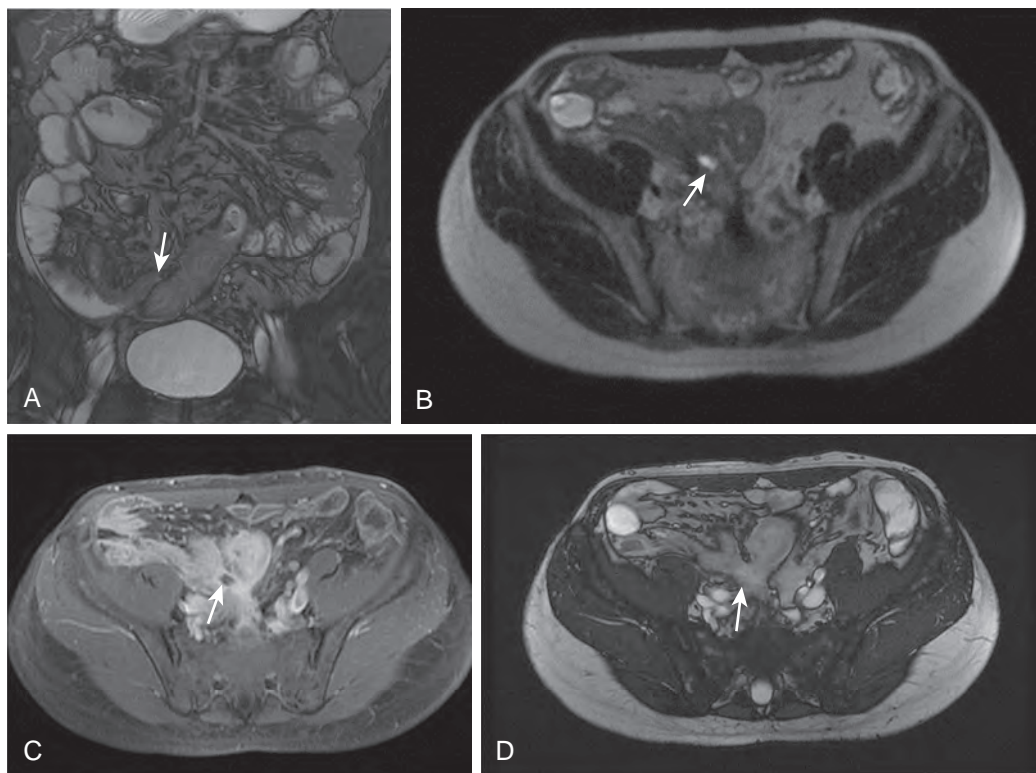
31-year-old man with fistulizing Crohn's disease subtype. A. Coronal true FISP image shows adherence between diseased distal ileal loops (arrow). B. Axial half-Fourier RARE image and axial contrast-enhanced, fat-saturated T1-weighted VIBE image (C) sequences showing a ileoileal fistula (arrow), with intense contrast enhancement because of their higher vascular flow and hyperemia, indicative of active inflammation. D. Axial true FISP image shows also desmoplastic and inflammatory reactions in the mesentery around the fistula, creating a stellar appearance (arrow). Multipplanar MR enterography is useful for a complete evaluation of the fistular tracts.
